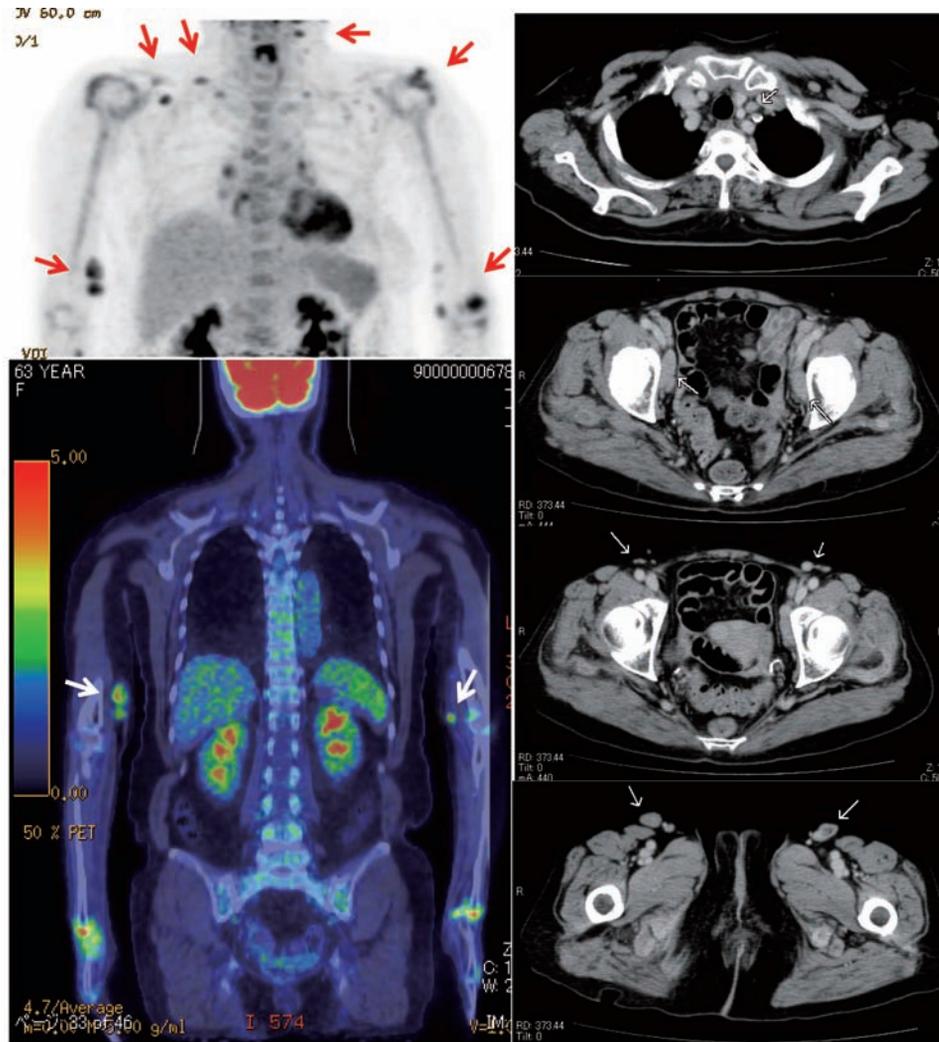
Radiological images. ^{18}F -fluorodeoxy glucose positron emission tomography and computed tomography revealed systemic lymphadenopathy; right brachial lymph node was biopsied.
